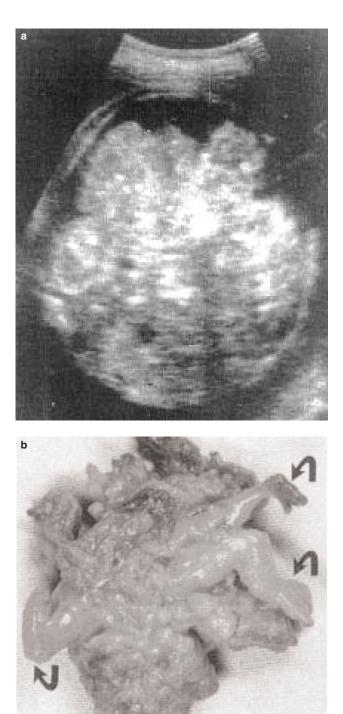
Fetus-*in-fetu*. This case was found in a miscarriage of 24 weeks. The sonographic scan (a) shows a large-for-dates fetal head (biparietal diameter 12.4 cm. head circumference 42 cm), with a large intracranial hyperechogenic and amorphic mass. The pathologic examination (b) revealed an immature teratoma, including well-defined fetal limbs. Images courtesy of I. Solt MD and I. Goldstein MD. Reprinted from *Am J Obstet Gynecol* Vol. 175. Goldstein I, Jakobi P, Groisman G, Itskovitz-Eldor J. Intracraninal fetus-*in-fetu*, 1389–90 (1990), with permission from Elsevier
